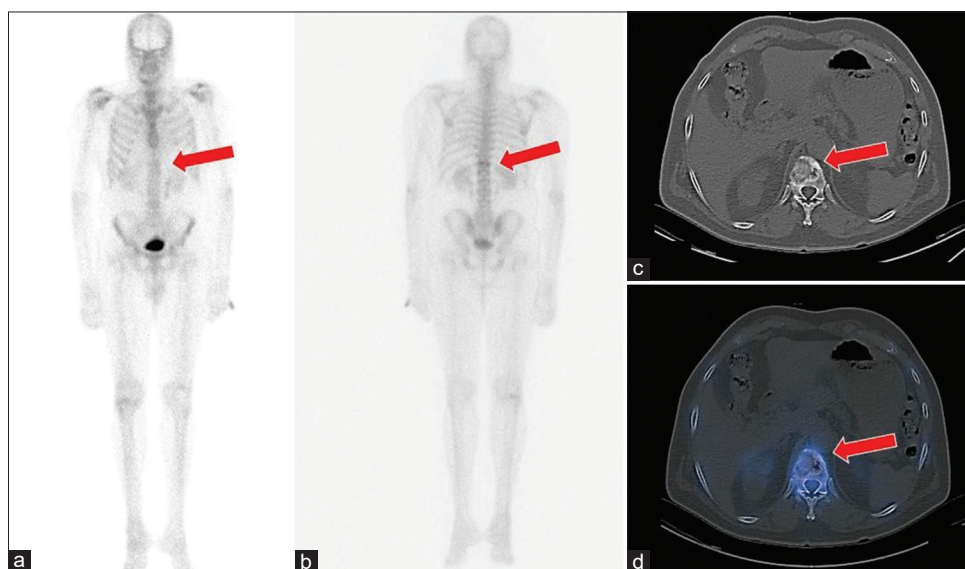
A 73-year-old man with bladder carcinoma, postchemotherapy. (a) Anterior and (b) posterior planar WBS revealed very subtle tracer uptake at the T12 vertebra (red arrow). (c) Plain CT, (d) Fused SPECT/CT images revealed subtle, low-grade tracer uptake of a pathological compression fracture at T12 vertebral body, with the associated lytic bone lesion (N. B. Bone scan is less sensitive in evaluating lytic bone lesions.). WBS: Whole-body bone scanning, SPECT/CT: Single-photon emission computed tomography/computed tomography
